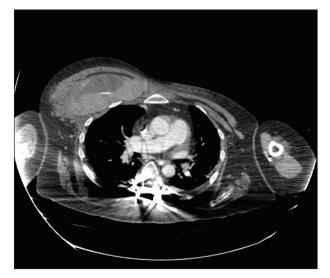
A CT scan showing active hemorrhage.
